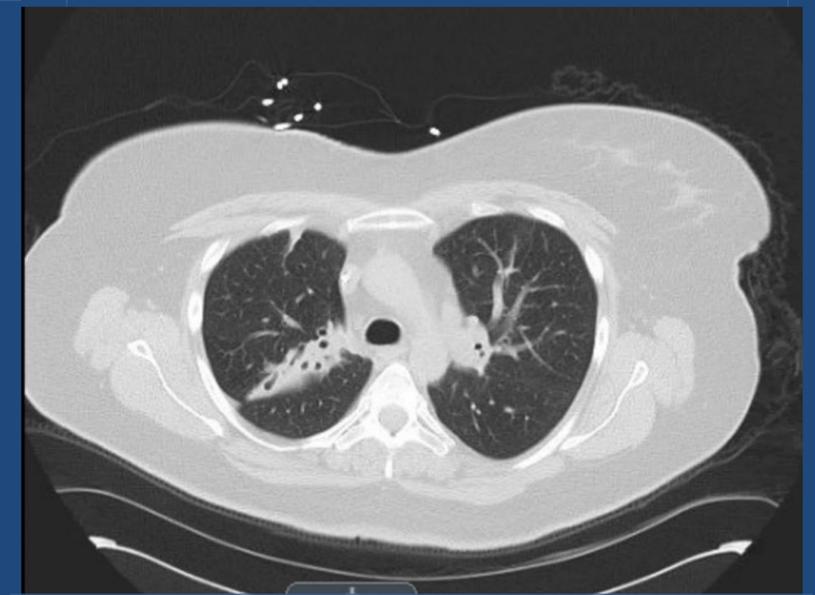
CT chest with IV contrast: When compared to the most recent prior CT 1 month ago, the bilateral upper lobe opacities are without significant change in dimension however there is now bronchiectasis involving the lesions. The multiple pleural parenchymal nodules involving the left lung apex are not appreciated in the current study.
